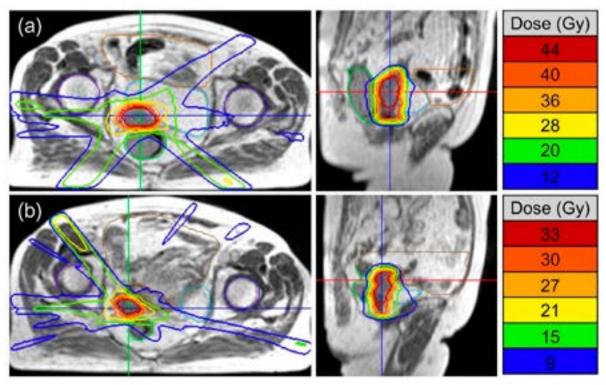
MRI-guided radiotherapy isodose lines with corresponding actual radiation doses. A. The initial plan. B. The adaptive plan
